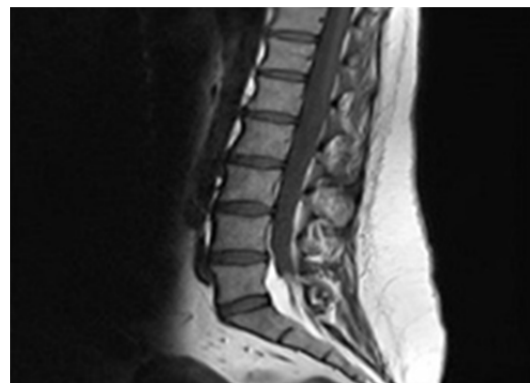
Sagittal T1-weighted MRI (short tau inversion recovery; STIR) shows epidural lipomatosis
